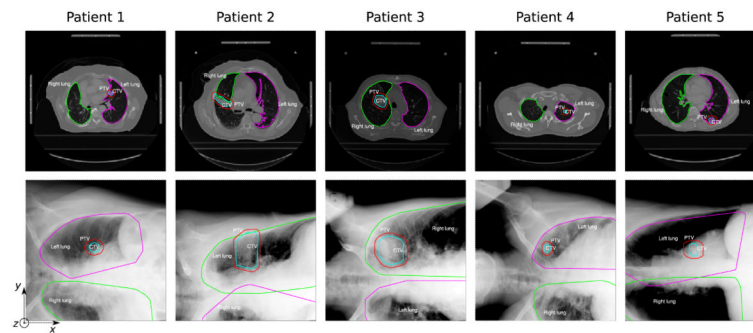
The patient data sets used for off-line validation of the method. One representative slice of the CT planning data for each patient with the contours of the right lung (green), left lung (magenta), CTV (cyan) and PTV (red) is shown in the first row. The second row shows the initial X-rays with the contours projected by the help of the initial transformation matrix T_{init} , the projected PTV is the ROI used for the registration of the X-ray to the CT planning.
